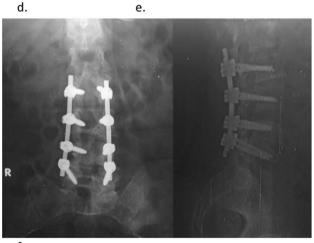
L3-4 spondylodiscitis. a-c Preoperative MRI of the lumbar spine showing L3-4 spondylodiscitis. d, e Preoperative CT of the lumbar spine showing L3-4 spondylodiscitis. f Postoperative antero-posterior and lateral radiographs showing L2-3-4-5 posterior trans-pedicular screw fixation with decompression
